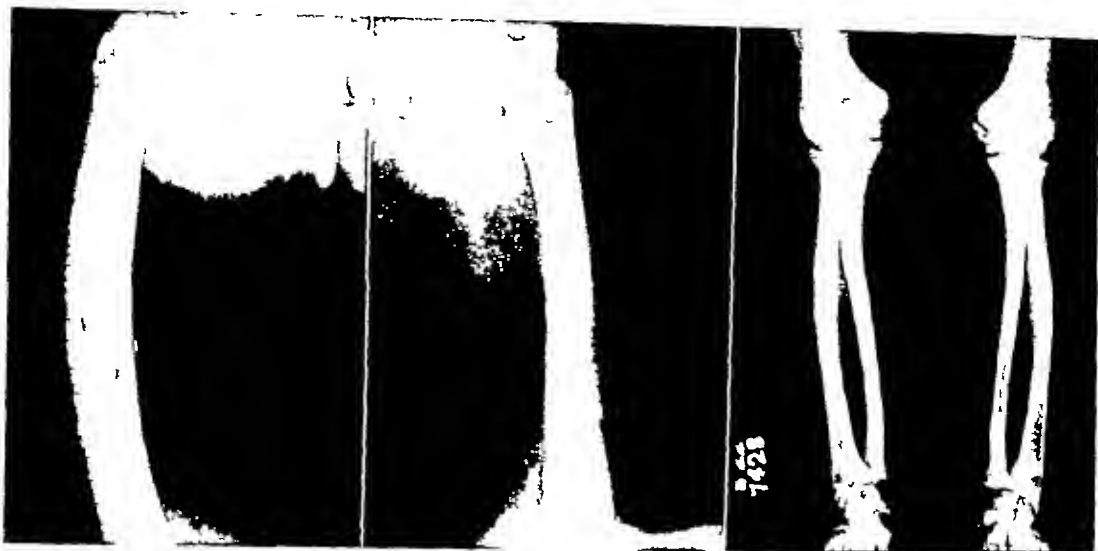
Broadening of the pelvis is characteristically seen under X-ray examination
